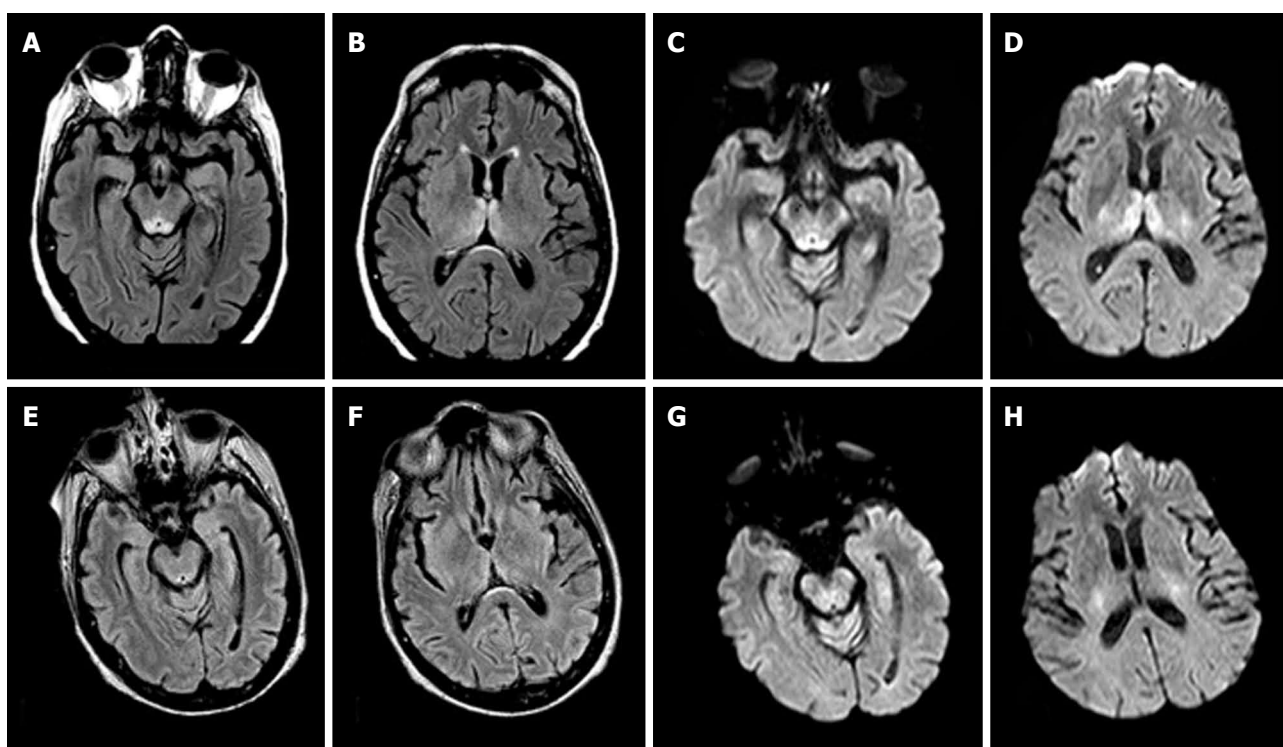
Magnetic resonance images in a patient affected by alcoholic Wernicke's encephalopathy. A-D: MR images before intravenous administration of thiamine therapy; E-H: MR images after intravenous administration of thiamine therapy. Axial FLAIR images (A,B) and DWI images (C,D) show signal abnormalities in the periaqueductal area and in the medial thalami. Axial FLAIR (E,F) and DWI (G,H) follow-up MR images, after intravenous administration of thiamine therapy, show resolution of the signal abnormalities previously observed. MR: Magnetic resonance; FLAIR: Fluid-attenuated inversion recovery; DWI: Diffusion weighted image.
